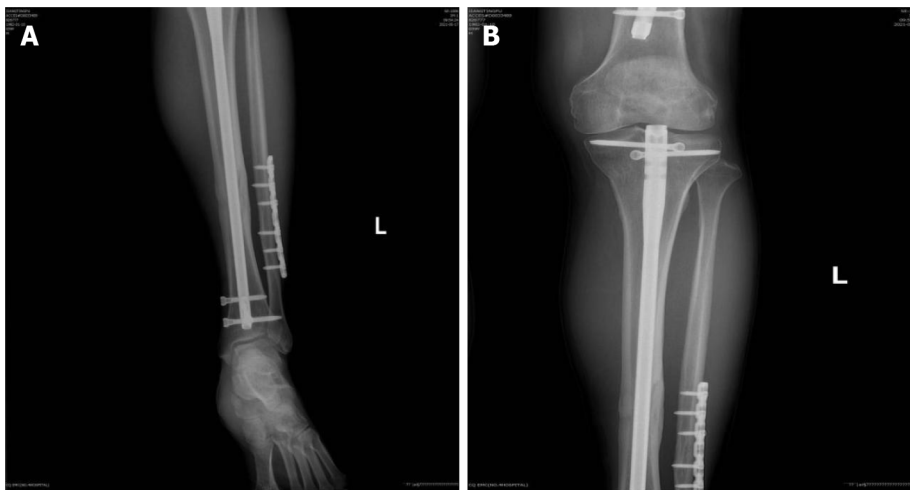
X-ray images of the patient's left proximal tibia. A: Antero-posterior X-ray view of the left proximal tibia showing complete bony union; B: Antero-posterior X-ray view of the left distal tibia showing complete bony union.
